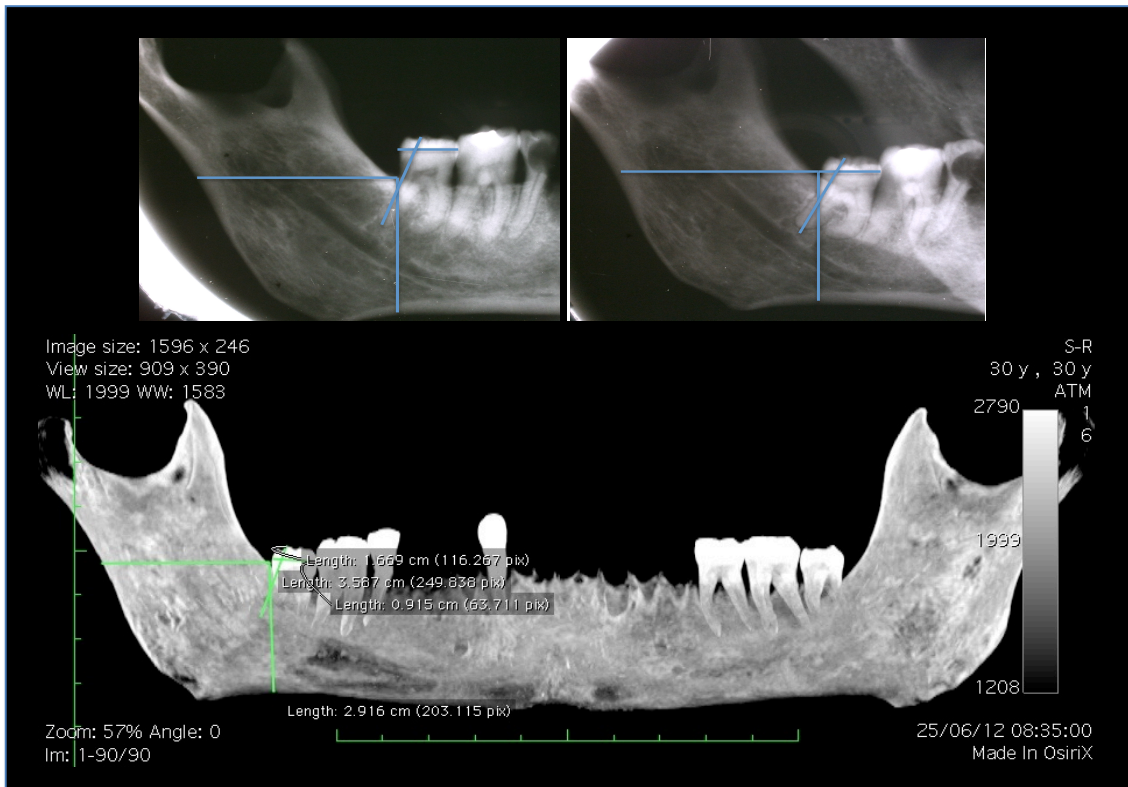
The lateral oblique radiographs and tomogram, showing the crown equator and the crown-radicular length of third molars (tooth length). And distance between distal alveolar crest of the third molar until mandibular base (vertical) and until posterior margin of the mandibular ramus (horizontal).
